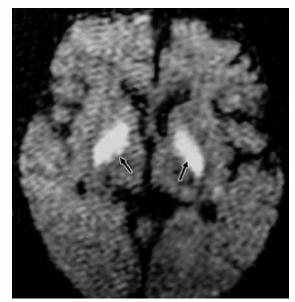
Diffusion-weighted MR image shows restricted diffusion in the bilateral globus pallidi (arrows).
